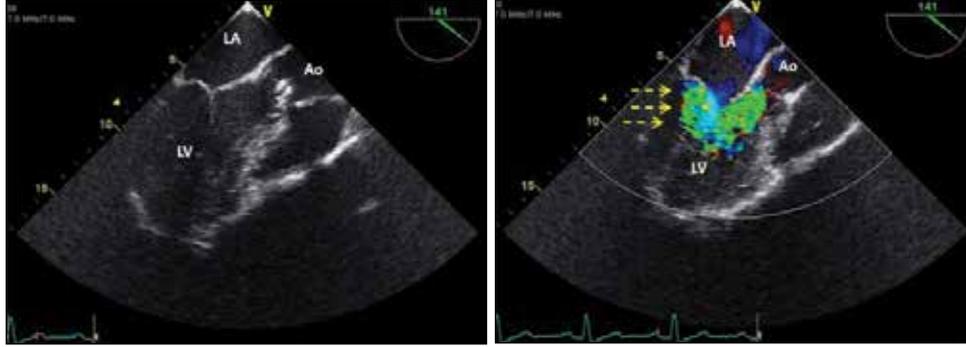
Transesophageal modified long-axis view of eccentric aortic regurgitation jet toward lateral mitral annulus
